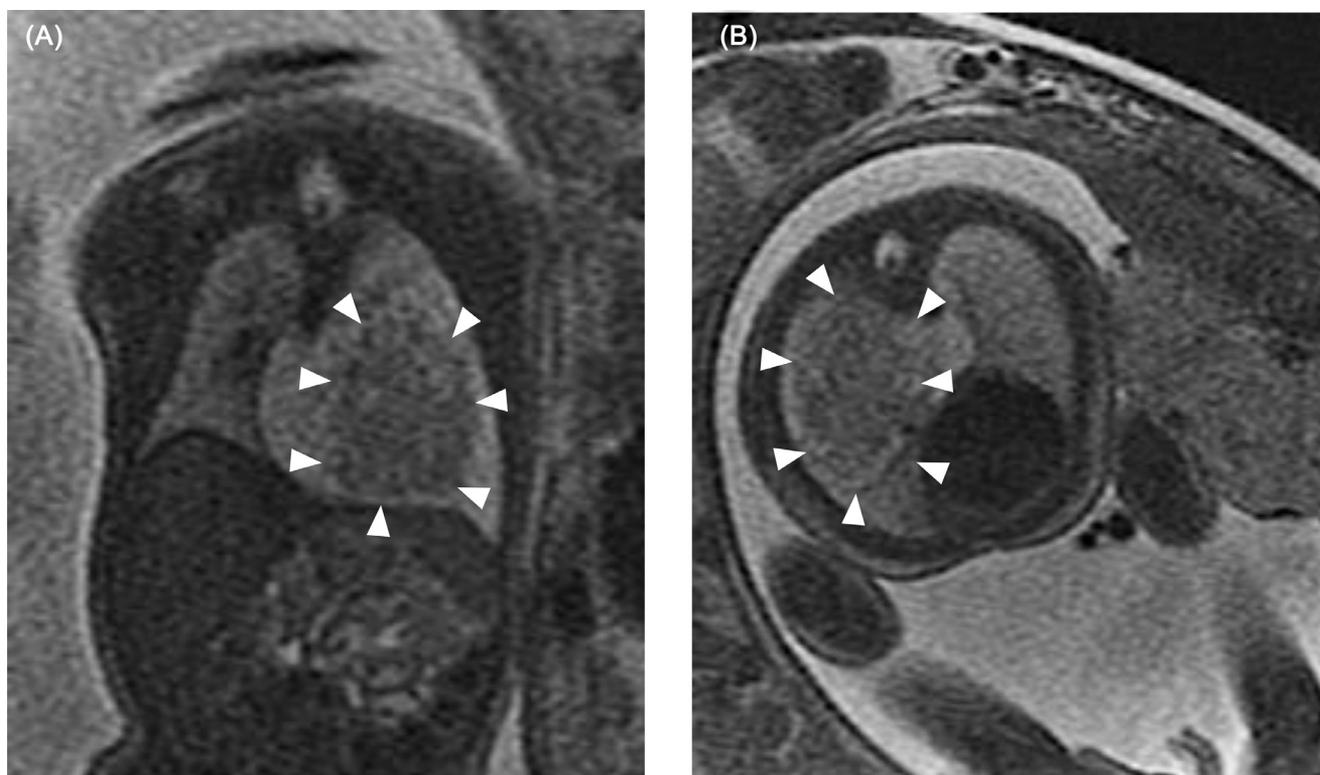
Coronal (A) and transverse (B) sections of T2-weighted MRI image of fetal CPMT. Note the T2- hypointense lung mass within the left lung (arrowhead).
